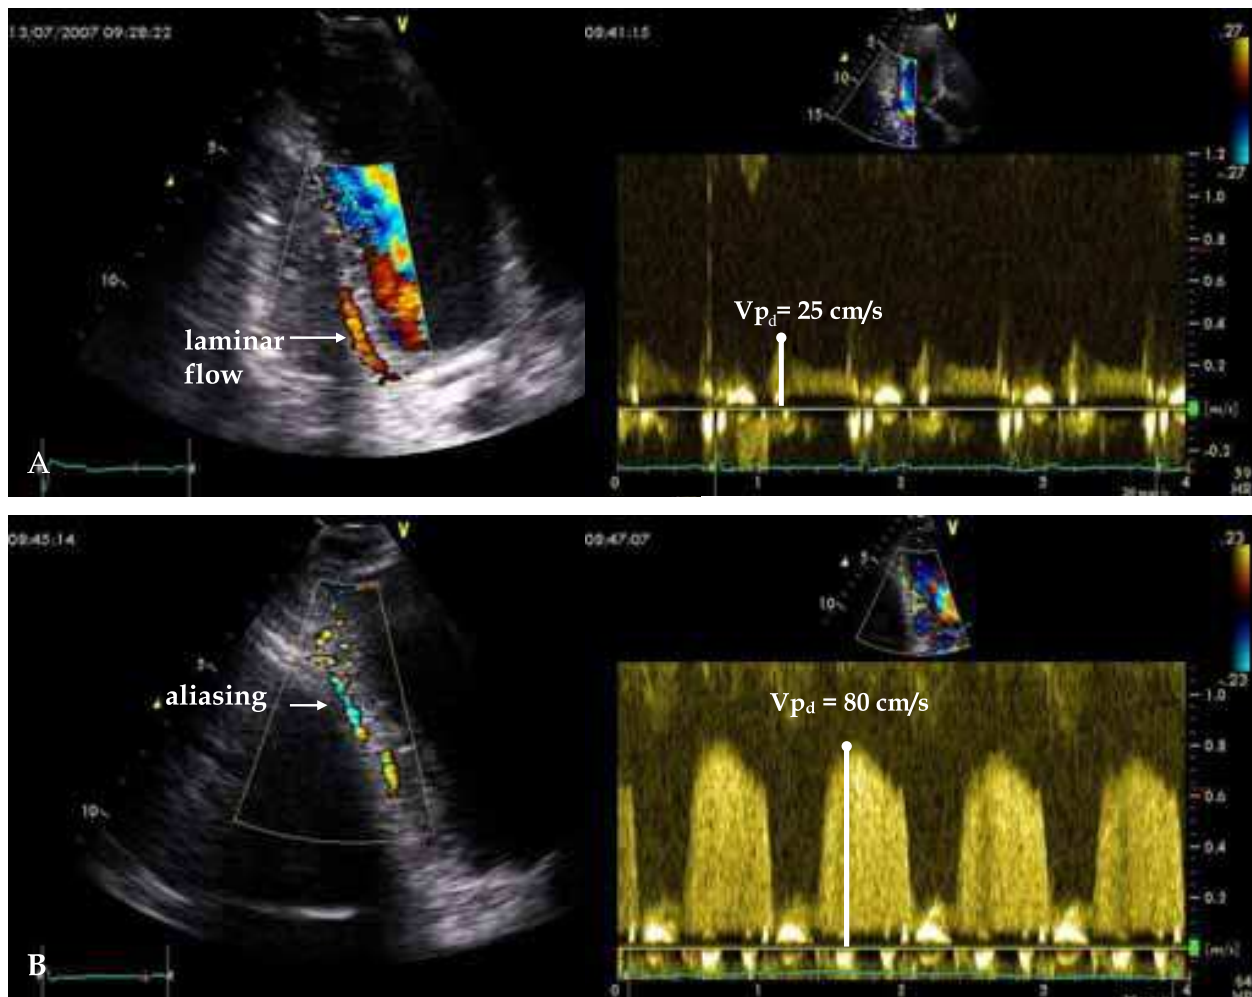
Examples of Color Doppler flow mapping of distal RCA presented by PDA: upper panel – patient C. without RCA stenosis: artery color flow map is red indicating low velocity with peak diastolic flow velocity ( $V_{pd}$ ) equal to 25 cm/s; lower panel – patient S. with 75% stenosis of mid RCA: Changes in the color flow map for color aliasing in the stenosis site and distal to it with  $V_{pd}$  acceleration up to 80 cm/s.
